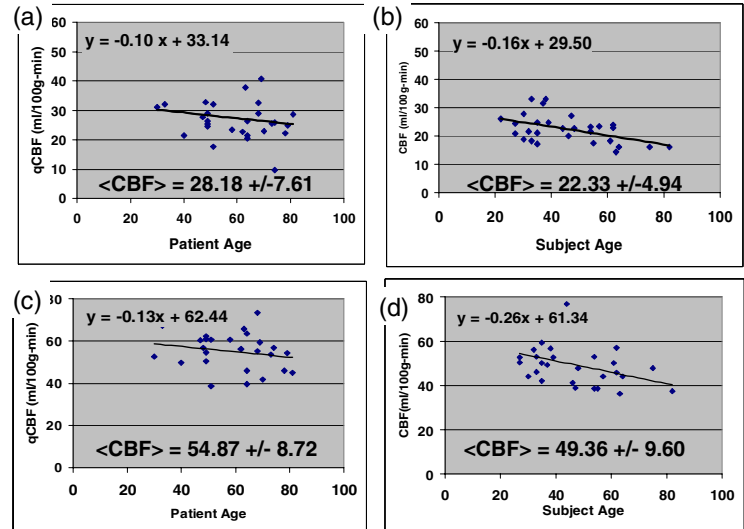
We have measured the age dependence of quantitative Cerebral Blood Flow (qCBF) in a series of 28 patients. We present the age dependence for (a) White Matter (WM) and (c) Gray Matter (GM) separately. (b) and (d) are previously reported H2[O15] PET qCBF values [2]. The trends seen in the MRI based measurements agree with the reference values provided by PET. Furthermore mean values are in agreement when pooled over patient.
